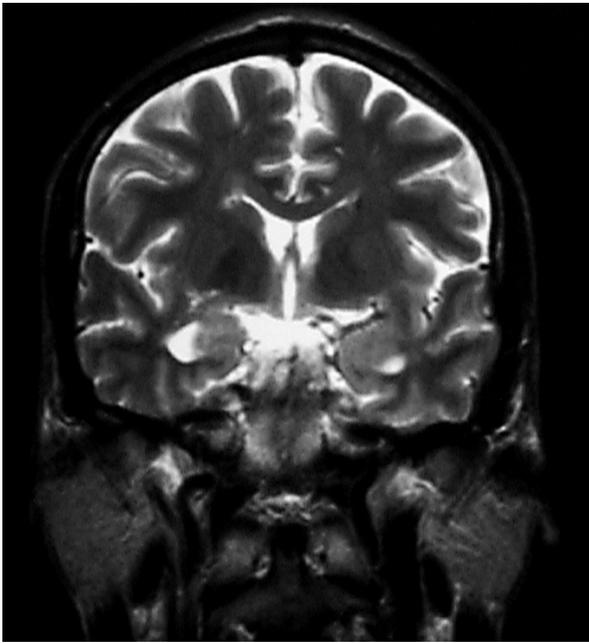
MRI Scan of the brain (coronal view). Note the course of the optic tract in relation to the third ventricle
